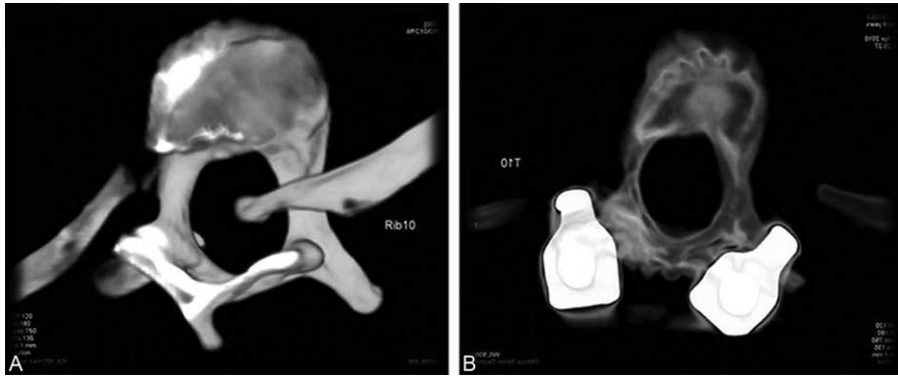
(A) Preoperative 3D-CT showed the intracanal portion of dislocated rib head; (B) postoperative 3D-CT showed that the intracanal rib head has removed completely; the spinal canal was very broad and smooth.
